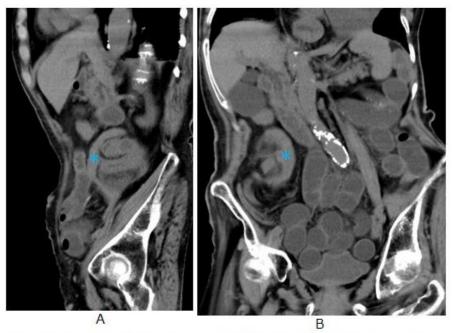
Sagittal and coronal CT depict that collection of small bowel is demonstrated in posterior (A) and lateral (B) area of cecum and ascending colon (*) where small bowel should be originally absent.
